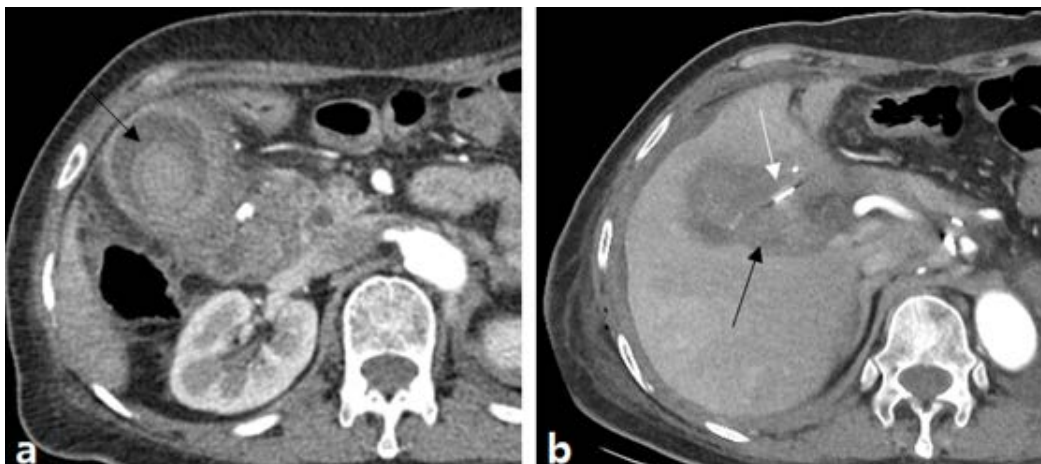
(a) Contrast-enhanced CT shows acute cholecystitis with a large gallbladder stone (arrow). (b) Contrast-enhanced CT following cholecystectomy reveals a fluid collection in the surgical bed (black arrow) and a Jackson-Pratt drainage catheter in place (white arrow).
